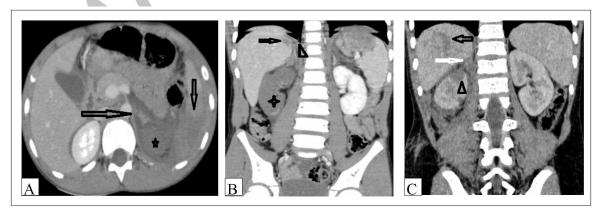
1A: 10-year-old male patient, after a traffic accident, axial CT images (a. left adrenal injury "horizontal arrow", b. left kidney injury "star", c. spleen injury "vertical arrow") Respectively. 1B: 7 -year-old male patient after a traffic accident, coronal CT image (a.Liver injury "horizontal arrow" b. right kidney injury "star" c.Right adrenal "head arrow") Respectively. 1C. 10-year-old male patient after falling from height, coronal CT image (a.Right adrenal injury "white arrow" b. Right kidneyinjury "head arrow c.liver "black arrow") Respectively.
